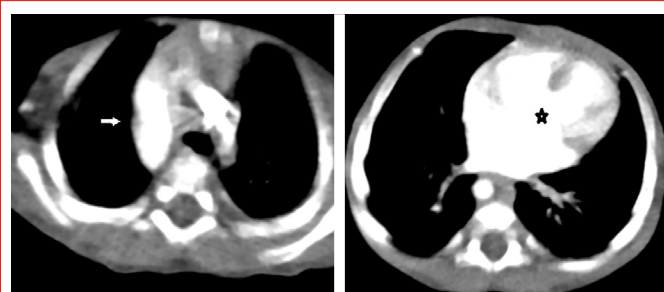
Contrast-enhanced thoracic CT images show a right-sided aortic arch (white arrow) and an atrioventricular septal defect (AVSD) (asterisk).
